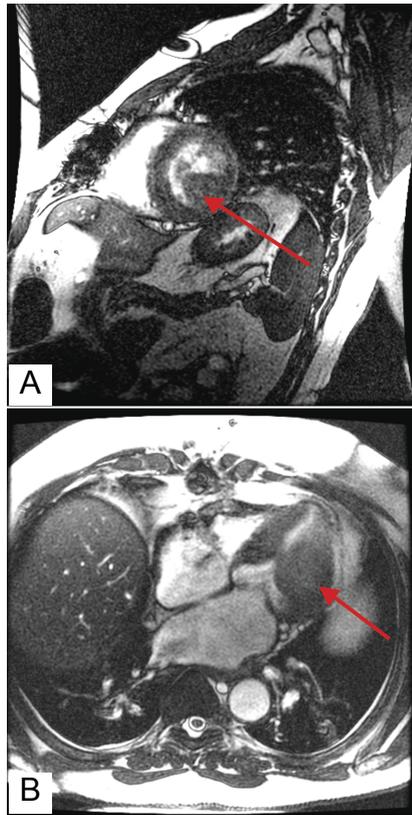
A FIESTA magnetic resonance image showing: (A) short axis oblique view, and (B) four-chamber oblique view, with red arrows pointing to the left ventricular wall mass.
